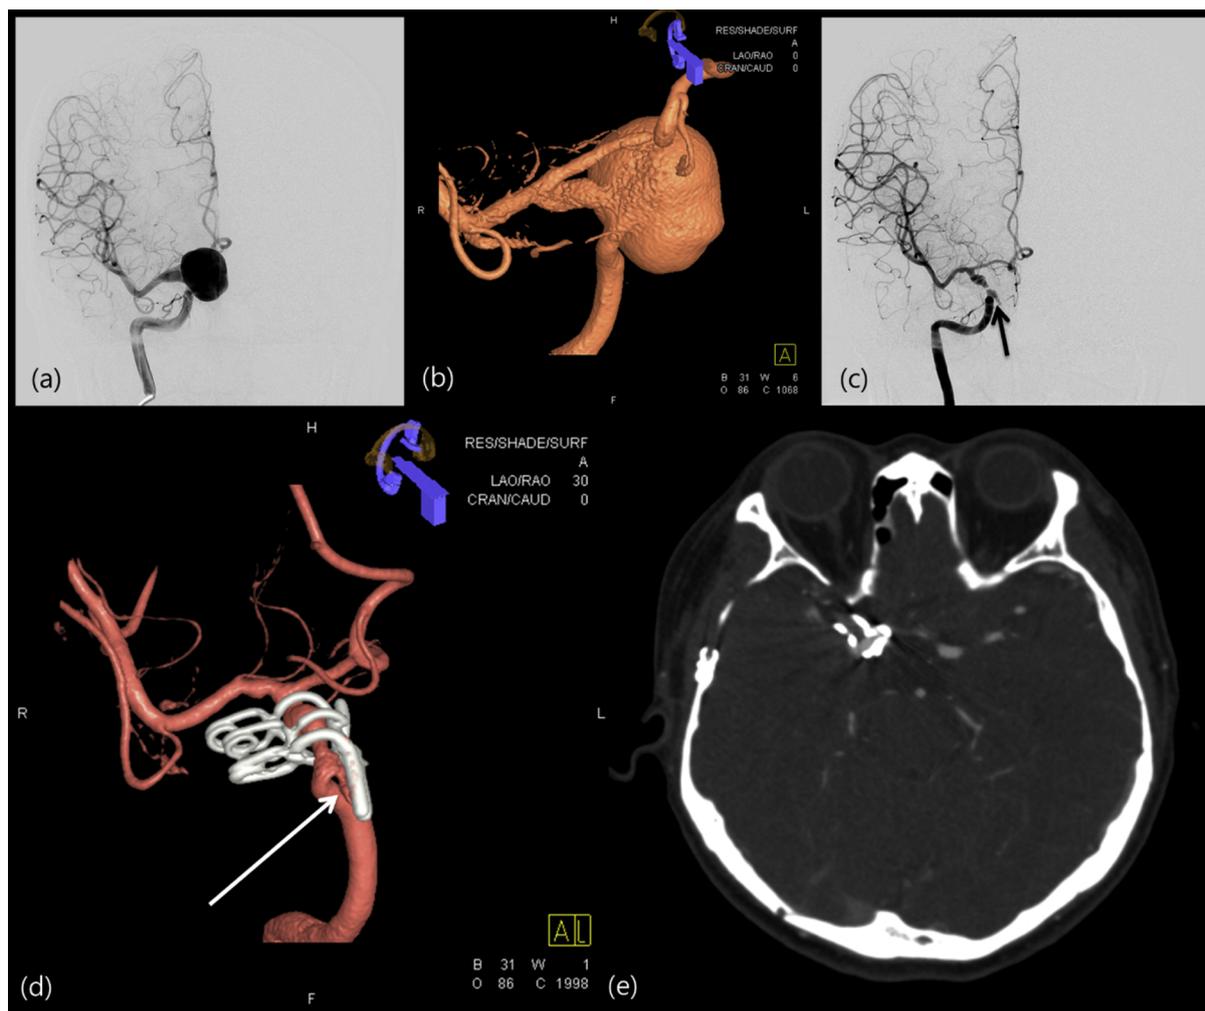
Evaluation results of a middle-aged female patient who developed visual disturbance. (a, b) Cerebral angiogram showing a 25-mm giant aneurysm of the right internal carotid artery. The aneurysm was a medial-directed, ophthalmic-segment aneurysm. (c, d) Adenosine 15 mg was used to generate asystole for about 50 s, for clipping. The postoperative angiogram showed minimal residual sac (black arrow and white arrow). (e) No recurrence was seen on the computed tomography angiogram obtained 7 months after treatment.
